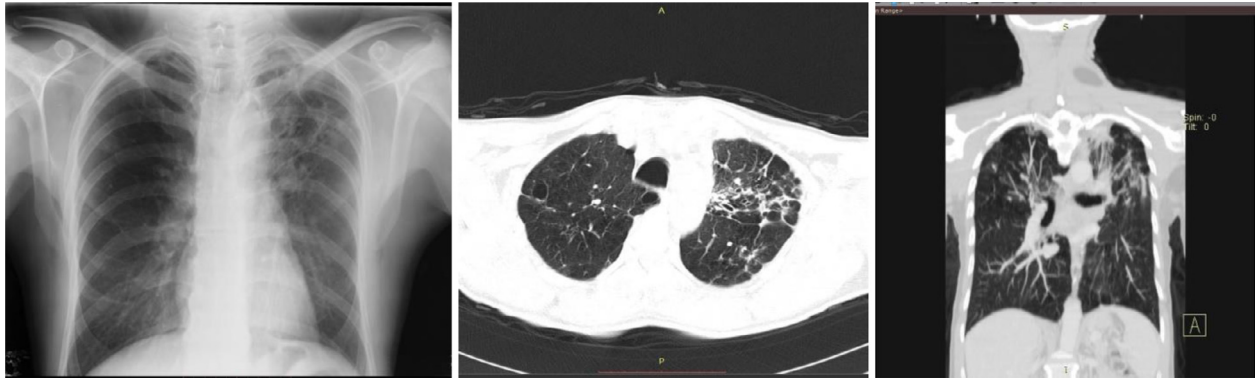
A year later, a second chest radiography and MSCT were conducted
